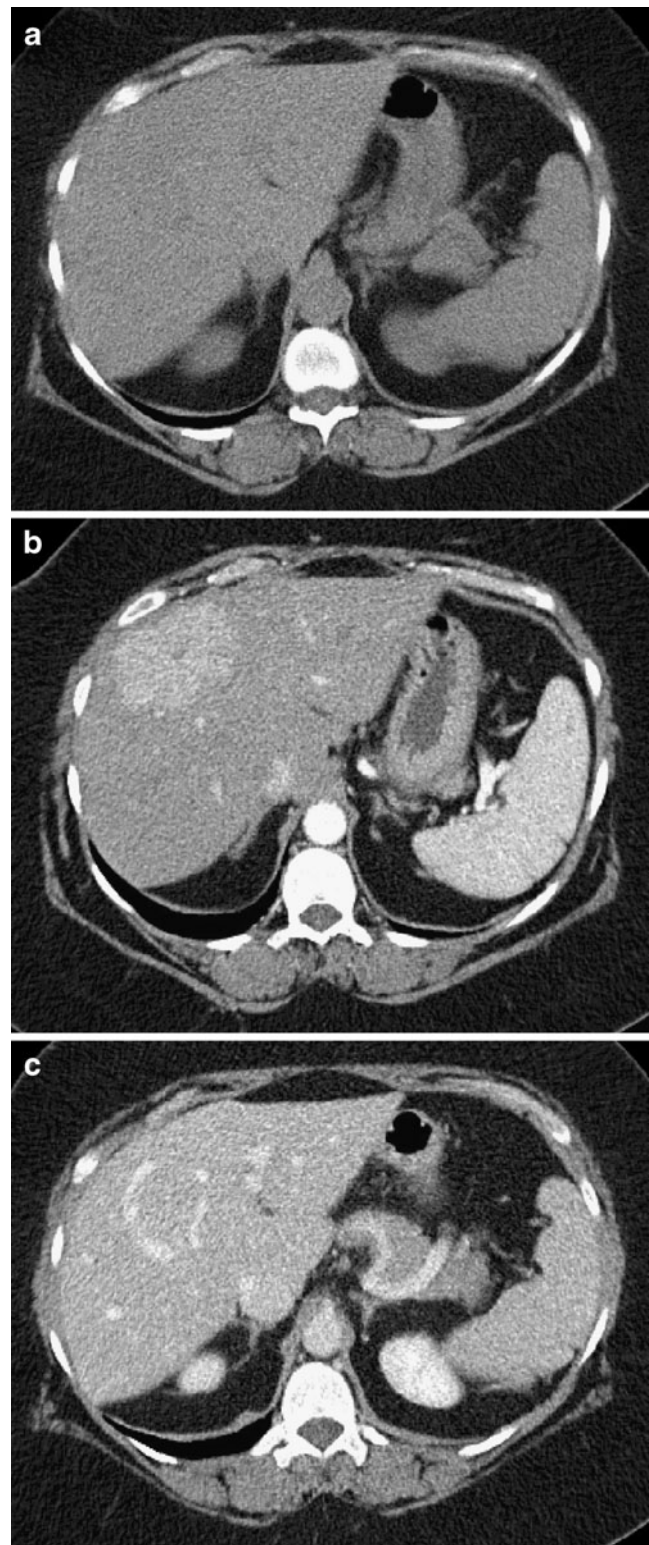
CT images of FNH during the a non-contrast phase, b arterial phase, and c portal venous phase. Note the hypodense central scar demonstrated on arterial phase and the discontinuous peripheral vascular rim on portal venous phase
